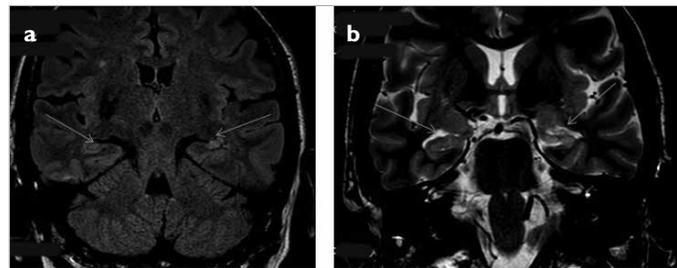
Bilateral hippocampal sclerosis with 3-T coronal MR imaging as demonstrated by our criteria; bilateral atrophy in T1-weight and high-signal FLAIR images bilaterally.
